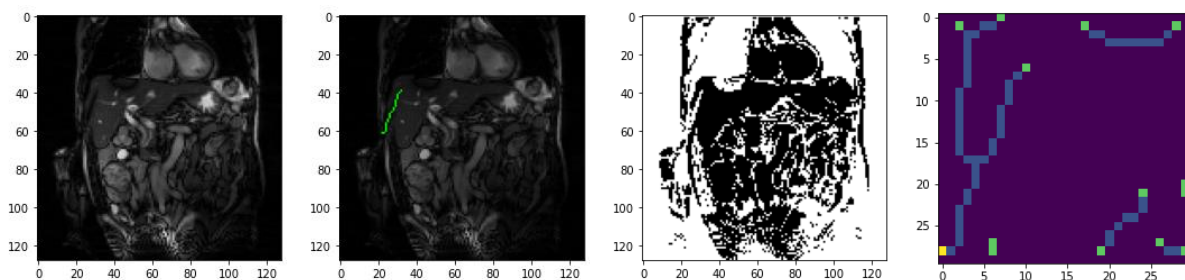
From left to right: Frontal generated MRI image, threshold-based (Otsu) segmentation, skeletonization with insertion point (yellow) and possible needle tips (green), most likely trajectory for the needle (green).
